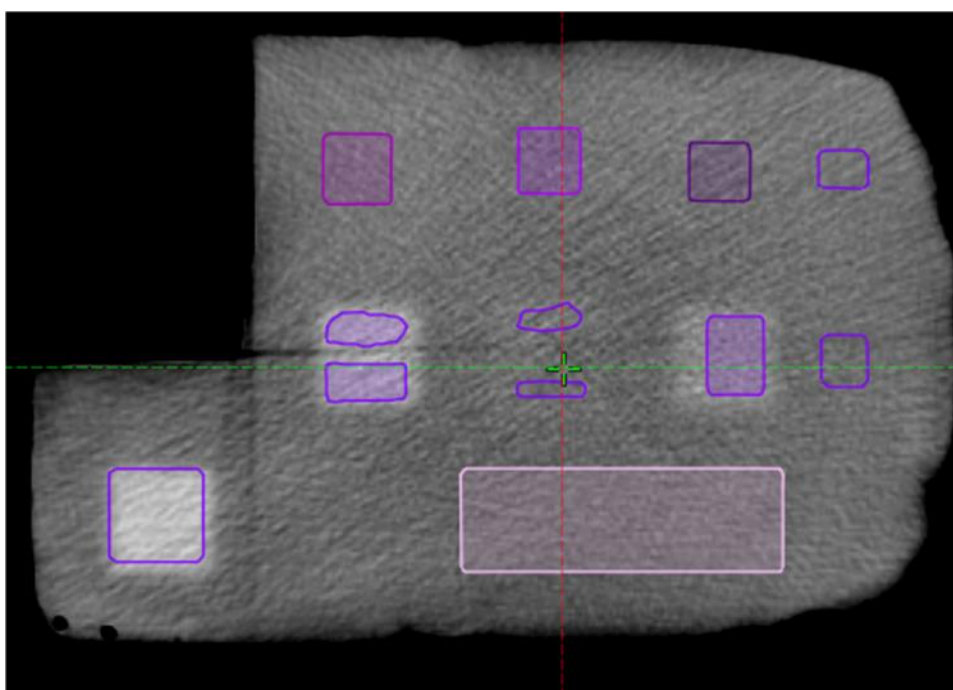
Diagnostic CT scan displaying how to take care of artefacts by preventing the dark spot in the mean CT numbers.
